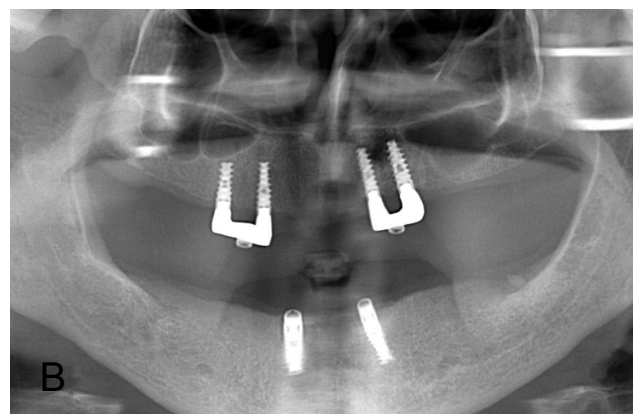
a, b. *Clinical and X-ray of anterior implant position.*
